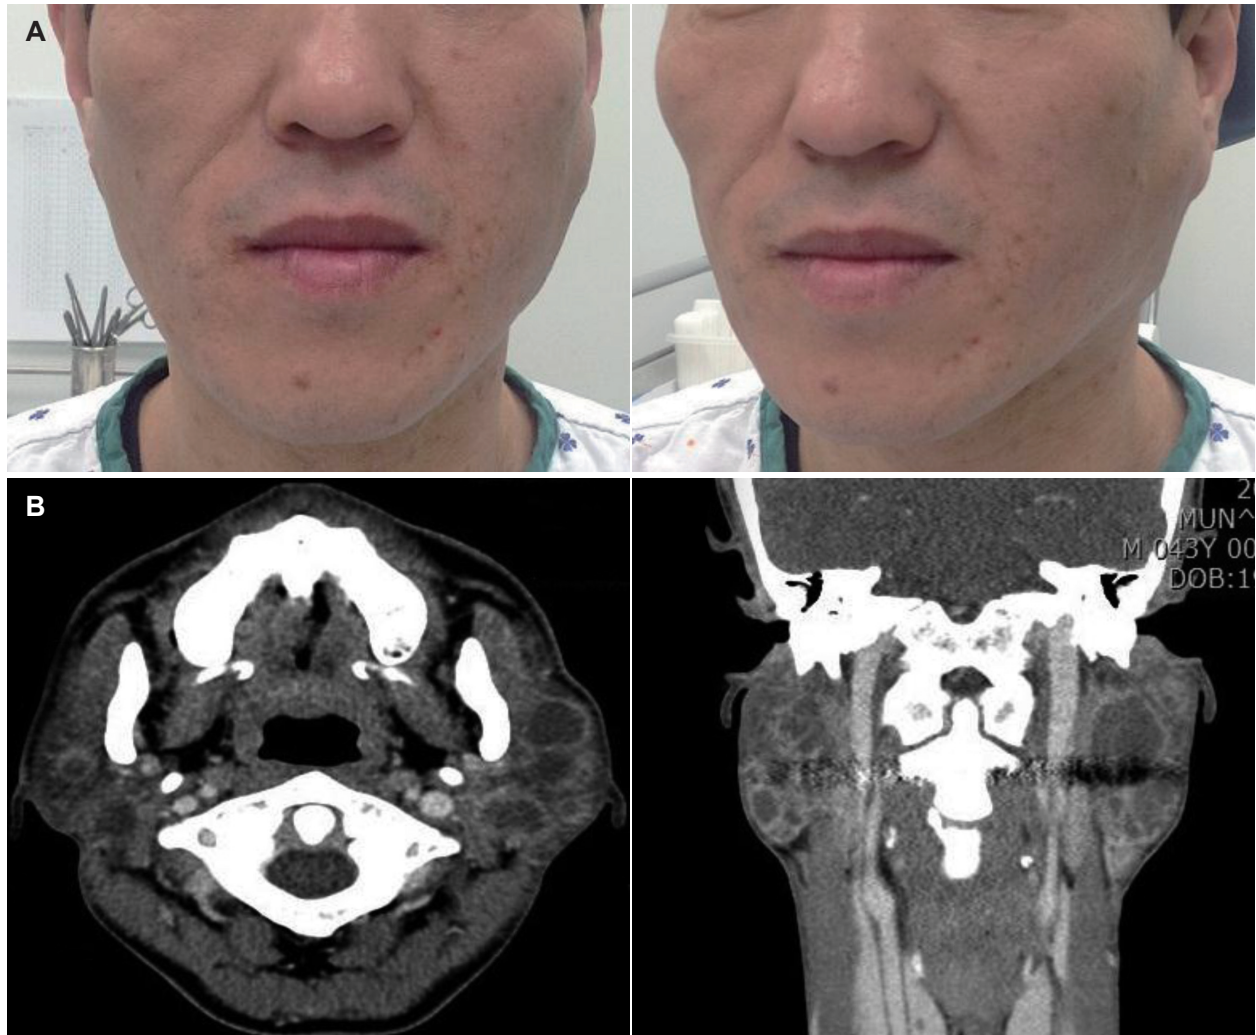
HIV-positive man with bilateral benign lymphoepithelial cysts (A). Computed tomography scan of HIV-positive patient with multi-loculated thin-walled cysts within both parotid glands. This is the typical radiographic presentation of benign lymphoepithelial cysts (B). HIV: human immunodeficiency virus.
